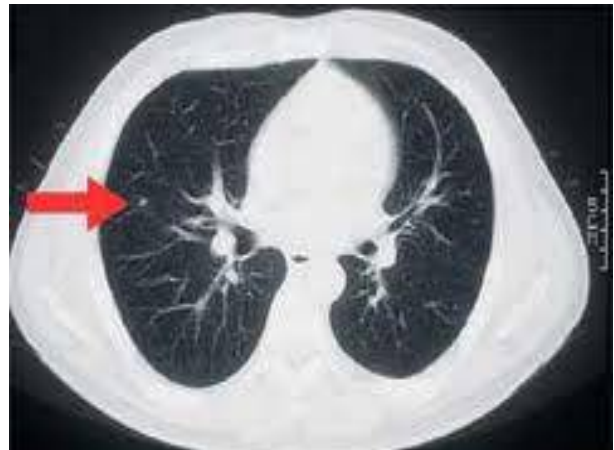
Cancerous Lung CT Image
